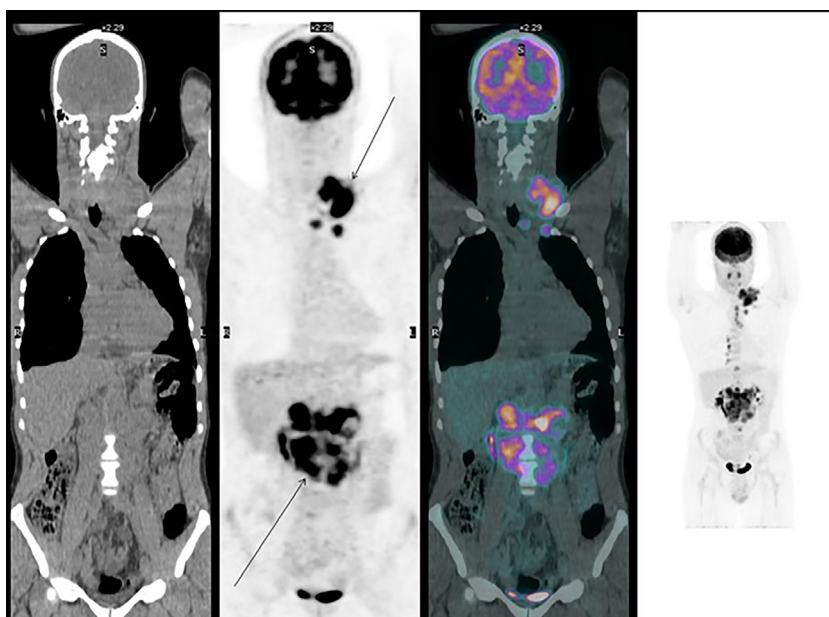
A Fluorodeoxyglucose Positron Emission Tomography (FDG-PET) revealed various hypermetabolic uptake and pathological accumulations of FDG in many contiguous regions, all suggestive of metastatic lymphonodal lesions: laterocervical, mediastinal, paratracheal, retroperitoneal, paravertebral.
